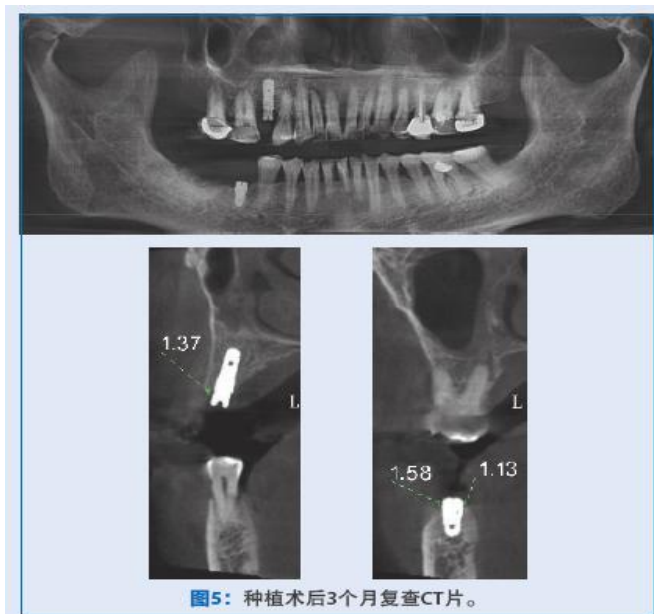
CT at reexamination 3 months after implantation.
